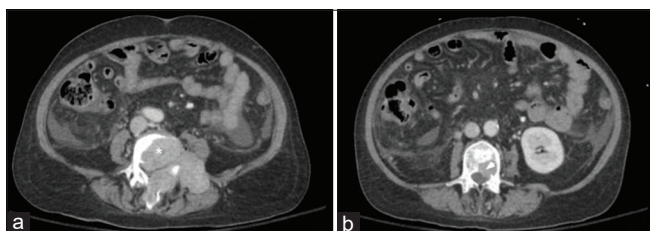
Axial computed tomography abdomen and pelvis demonstrating L4 vertebral body destructive metastases (*) with extraosseous extension into the spinal canal, spinous process, and left paraspinous musculature measuring 7.8 × 7.1 cm (a) and L3 posterior vertebral body metastasis (arrow head) with intraosseous extension into the spinal canal measuring 2.1 × 2.0 cm (b).
